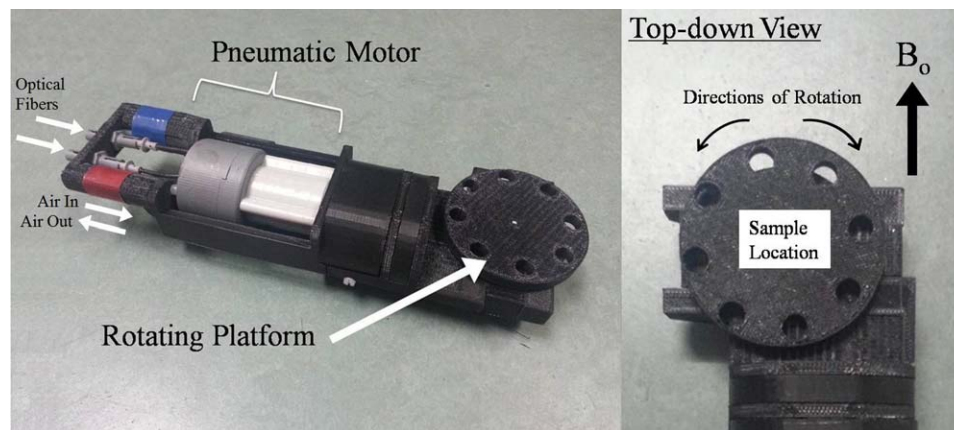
Images of the custom-made MR-compatible pneumatic automated rotating positioner used in the magic angle-enhanced MRI experiments. The *left panel* shows the general features of the rotating positioner. The *right panel* shows an enlarged top-down view of the rotating platform. Eye and tendon tissues were stabilized on the rotating platform. The angle between the tissues and the main magnetic field (B_0) was adjusted by rotating the platform driven by the pneumatic motor, using the LabView software program.
